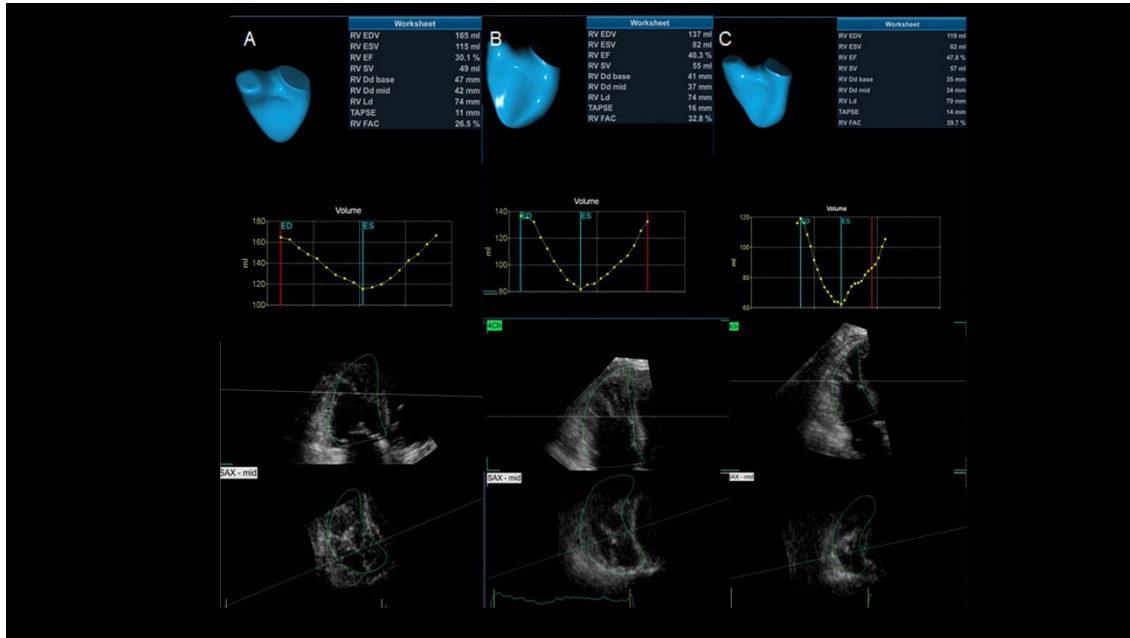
Follow-up 3D echocardiographic analysis of the right ventricle (RV), with measurement of RV end-diastolic volume (EDV), end-systolic volume (ESV), and ejection fraction (EF). Patient with submassive pulmonary embolism at 3 time points: A: pre-thrombolysis (RV EDV = 165 mL, RV ESV = 115 mL, RV EF = 30%); B: day 2 after thrombolysis (RV EDV = 137 mL, RV ESV = 82 mL, RV EF = 40%); C: day 5 after thrombolysis (RV EDV = 113 mL, RV ESV = 62 mL, RV EF = 47.8%).
